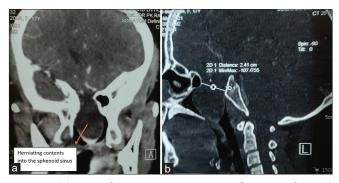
(a) Coronal section contrast computed tomography (CT) scan showing a nonenhancing isointense soft-tissue mass herniating into the sphenoid sinus reaching up to the floor. (b): Sagittal section bone window CT scan showing defect size of 2.4 cm in the sellar floor with herniating soft-tissue contents.
